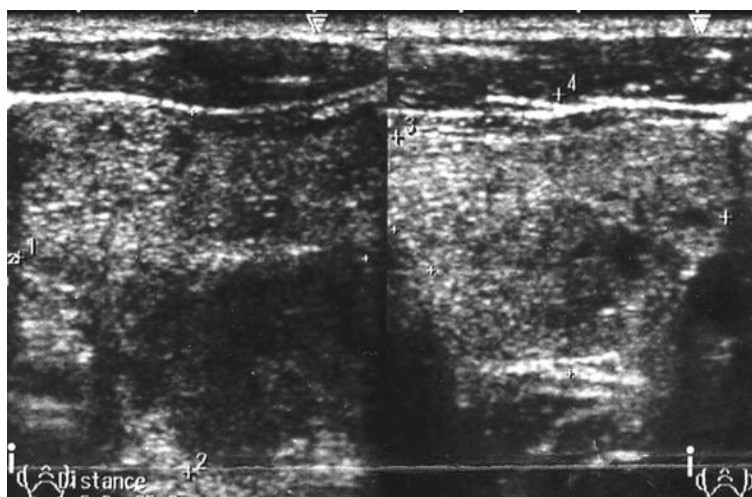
Thyroid ultrasonography revealed multiple nodules (biggest 1 cm) in the left thyroid gland 1 cm and a 4 cm nodule was found in the right thyroid gland.
